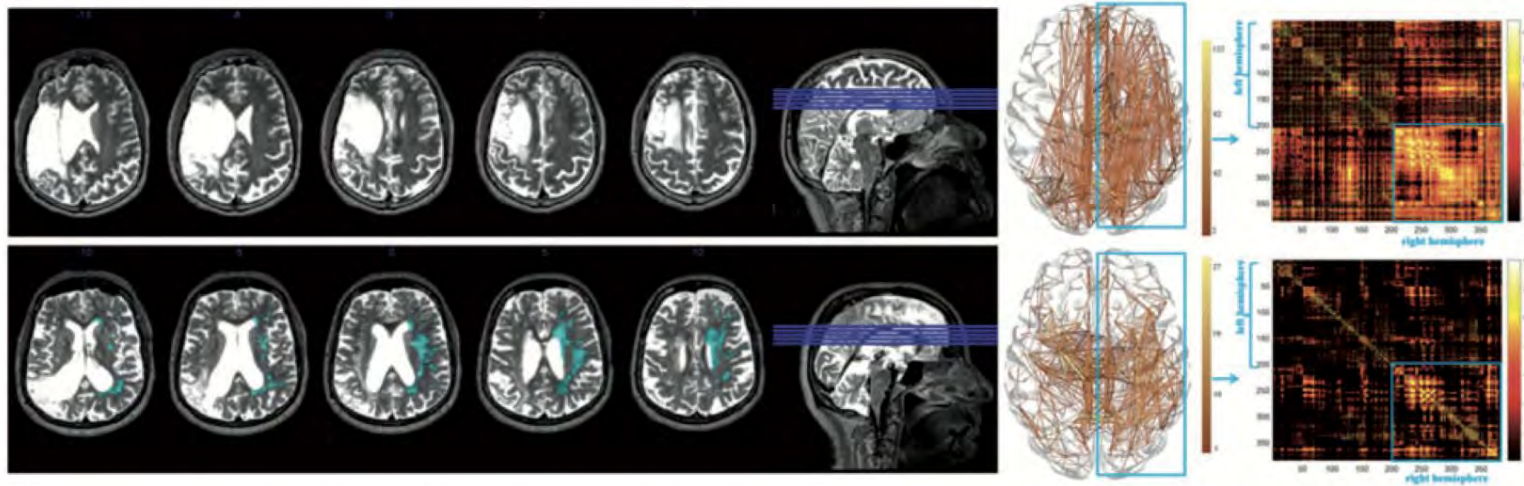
T₂-weighted MRI images from two patients of the study sample. Examples of PVH and deep WMH ratings (left: WMH are highlighted in light blue), as well as the corresponding fibre tracking and structural connectome matrix (right: x- and y-axes correspond to the AICHA region of interest numbers, warmer colours represent higher connectivity between regions of interest). Patient 1 (top row) did not present with WMH; Patient 2 (bottom row) presented with the most severe scores (3 for PVH and 3 for deep WMH). The connectome matrices show that the more severe WMH scores for Patient 2 coincided with fewer connections, particularly in brain areas with long range projections such as the frontal lobe, compared to Patient 1.
